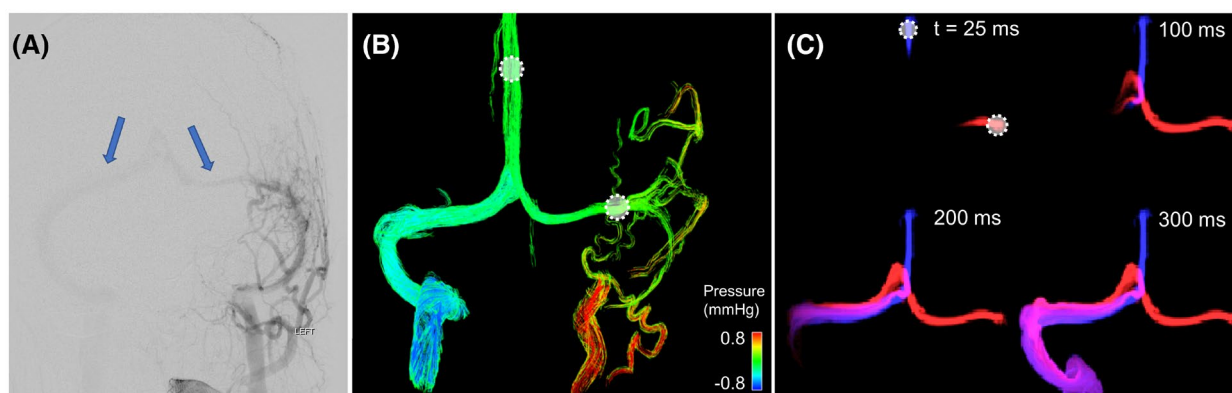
A, Digital subtraction angiography (DSA) image of a left external carotid injection showing a left transverse sinus dural arteriovenous fistula (DAVF) and potential reflux (arrows) into the right transverse sinus. B, The 4D-flow MRI-derived pressure mapping in the dural sinuses indicates increased intravascular pressure within the left transverse sinus. The two dashed circles represent seed point locations for streamline generation. C, Selective anterograde virtual injections in the superior sagittal sinus (blue) and left transverse sinus (red) are shown at four time frames. Note the retrograde flow away from the DAVF, corroborating results from DSA
